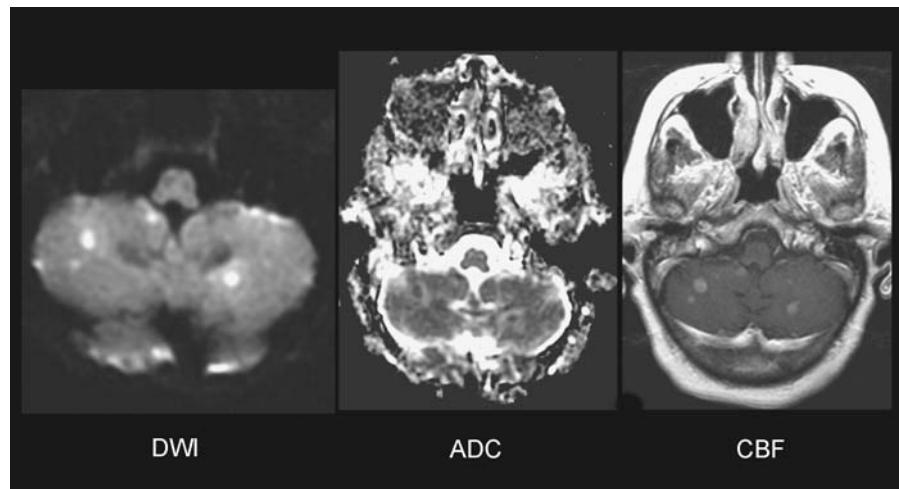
Small cell lung carcinoma metastases. There are multiple, bilateral cerebellar lesions that are DWI hyperintense and ADC hypointense, consistent with decreased diffusion, which mimic acute infarctions. On gadolinium-enhanced T1-weighted images, the lesions homogeneously enhance, which is most consistent with metastases. Abbreviations: DWI, diffusion-weighted images; ADC, apparent diffusion coefficient.
